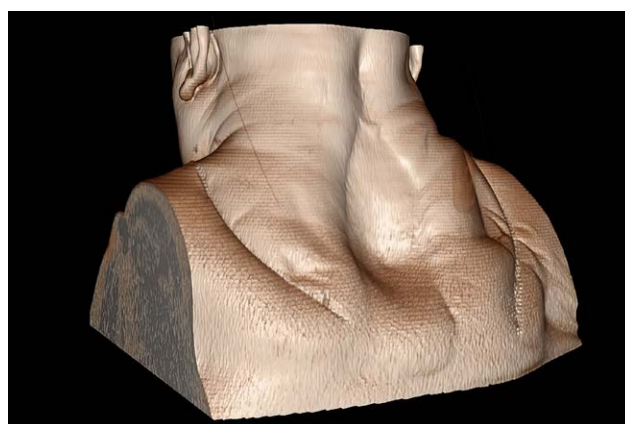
Three-dimensional reconstruction of CT scan depicting the flap “sunken” into the wound cavity in patient 13, in line with clinical findings seen.
